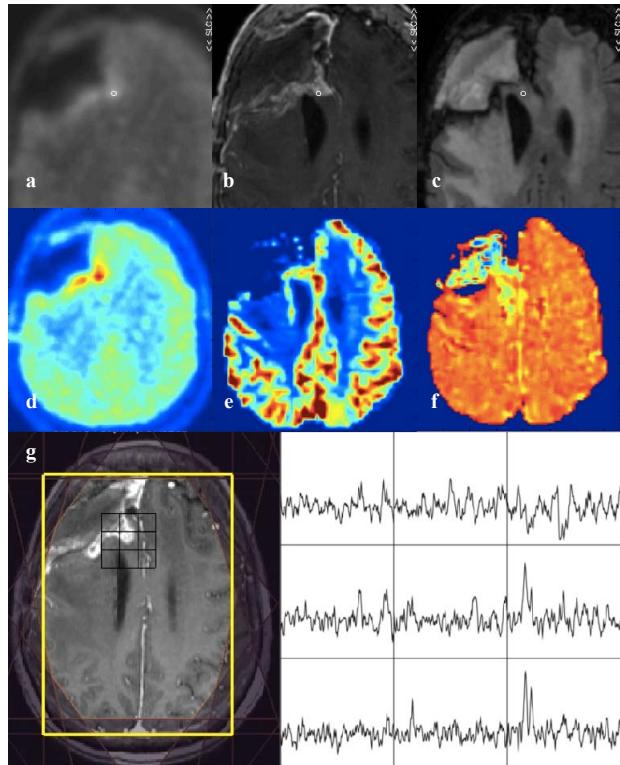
^{18}F -FMISO-PET (a), post-Gd T1-weighted (b), T2-weighted (c) images, T/B (0-1.1) (d), nCBV (0-3) (e), Rec (0-100) (f) maps and corresponding MRSI (g) acquired from patient B, who were clinically deteriorated in the next month without significant changes on MRI. The region of interest defines where $\text{T/B} \geq 1.1$.
